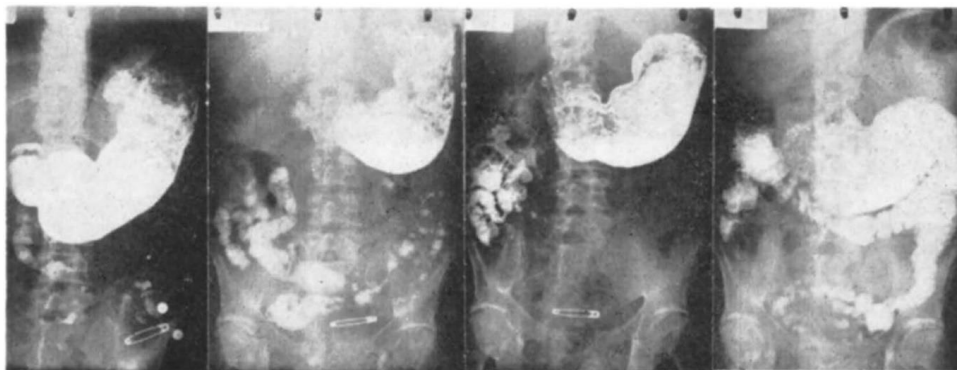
Abdominal radiographs of a patient with type 1 diabetes and severe gastric retention of a barium sulphate meal. Pictures were taken immediately after meal intake (left to right), after three, six, and 24 hours. Image originally published in “Asymptomatic gastric retention in diabetics (gastroparesis diabeticorum)” by Paul Kassander, *Annals of Internal Medicine* (Volume 48, Issue 4, Apr 1 1958). Reprinted with permission from The American College of Physicians and Copyright Clearance Center.
